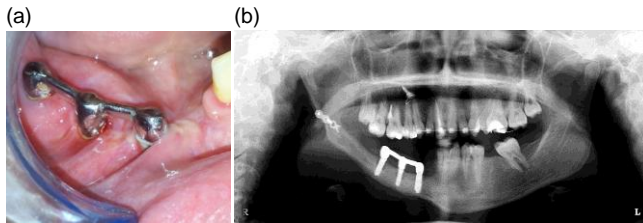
(a) Showing intraoral view of three implants splinted with bar inserted in the right side of partially edentulous reconstructed mandible (b) radiographic view
